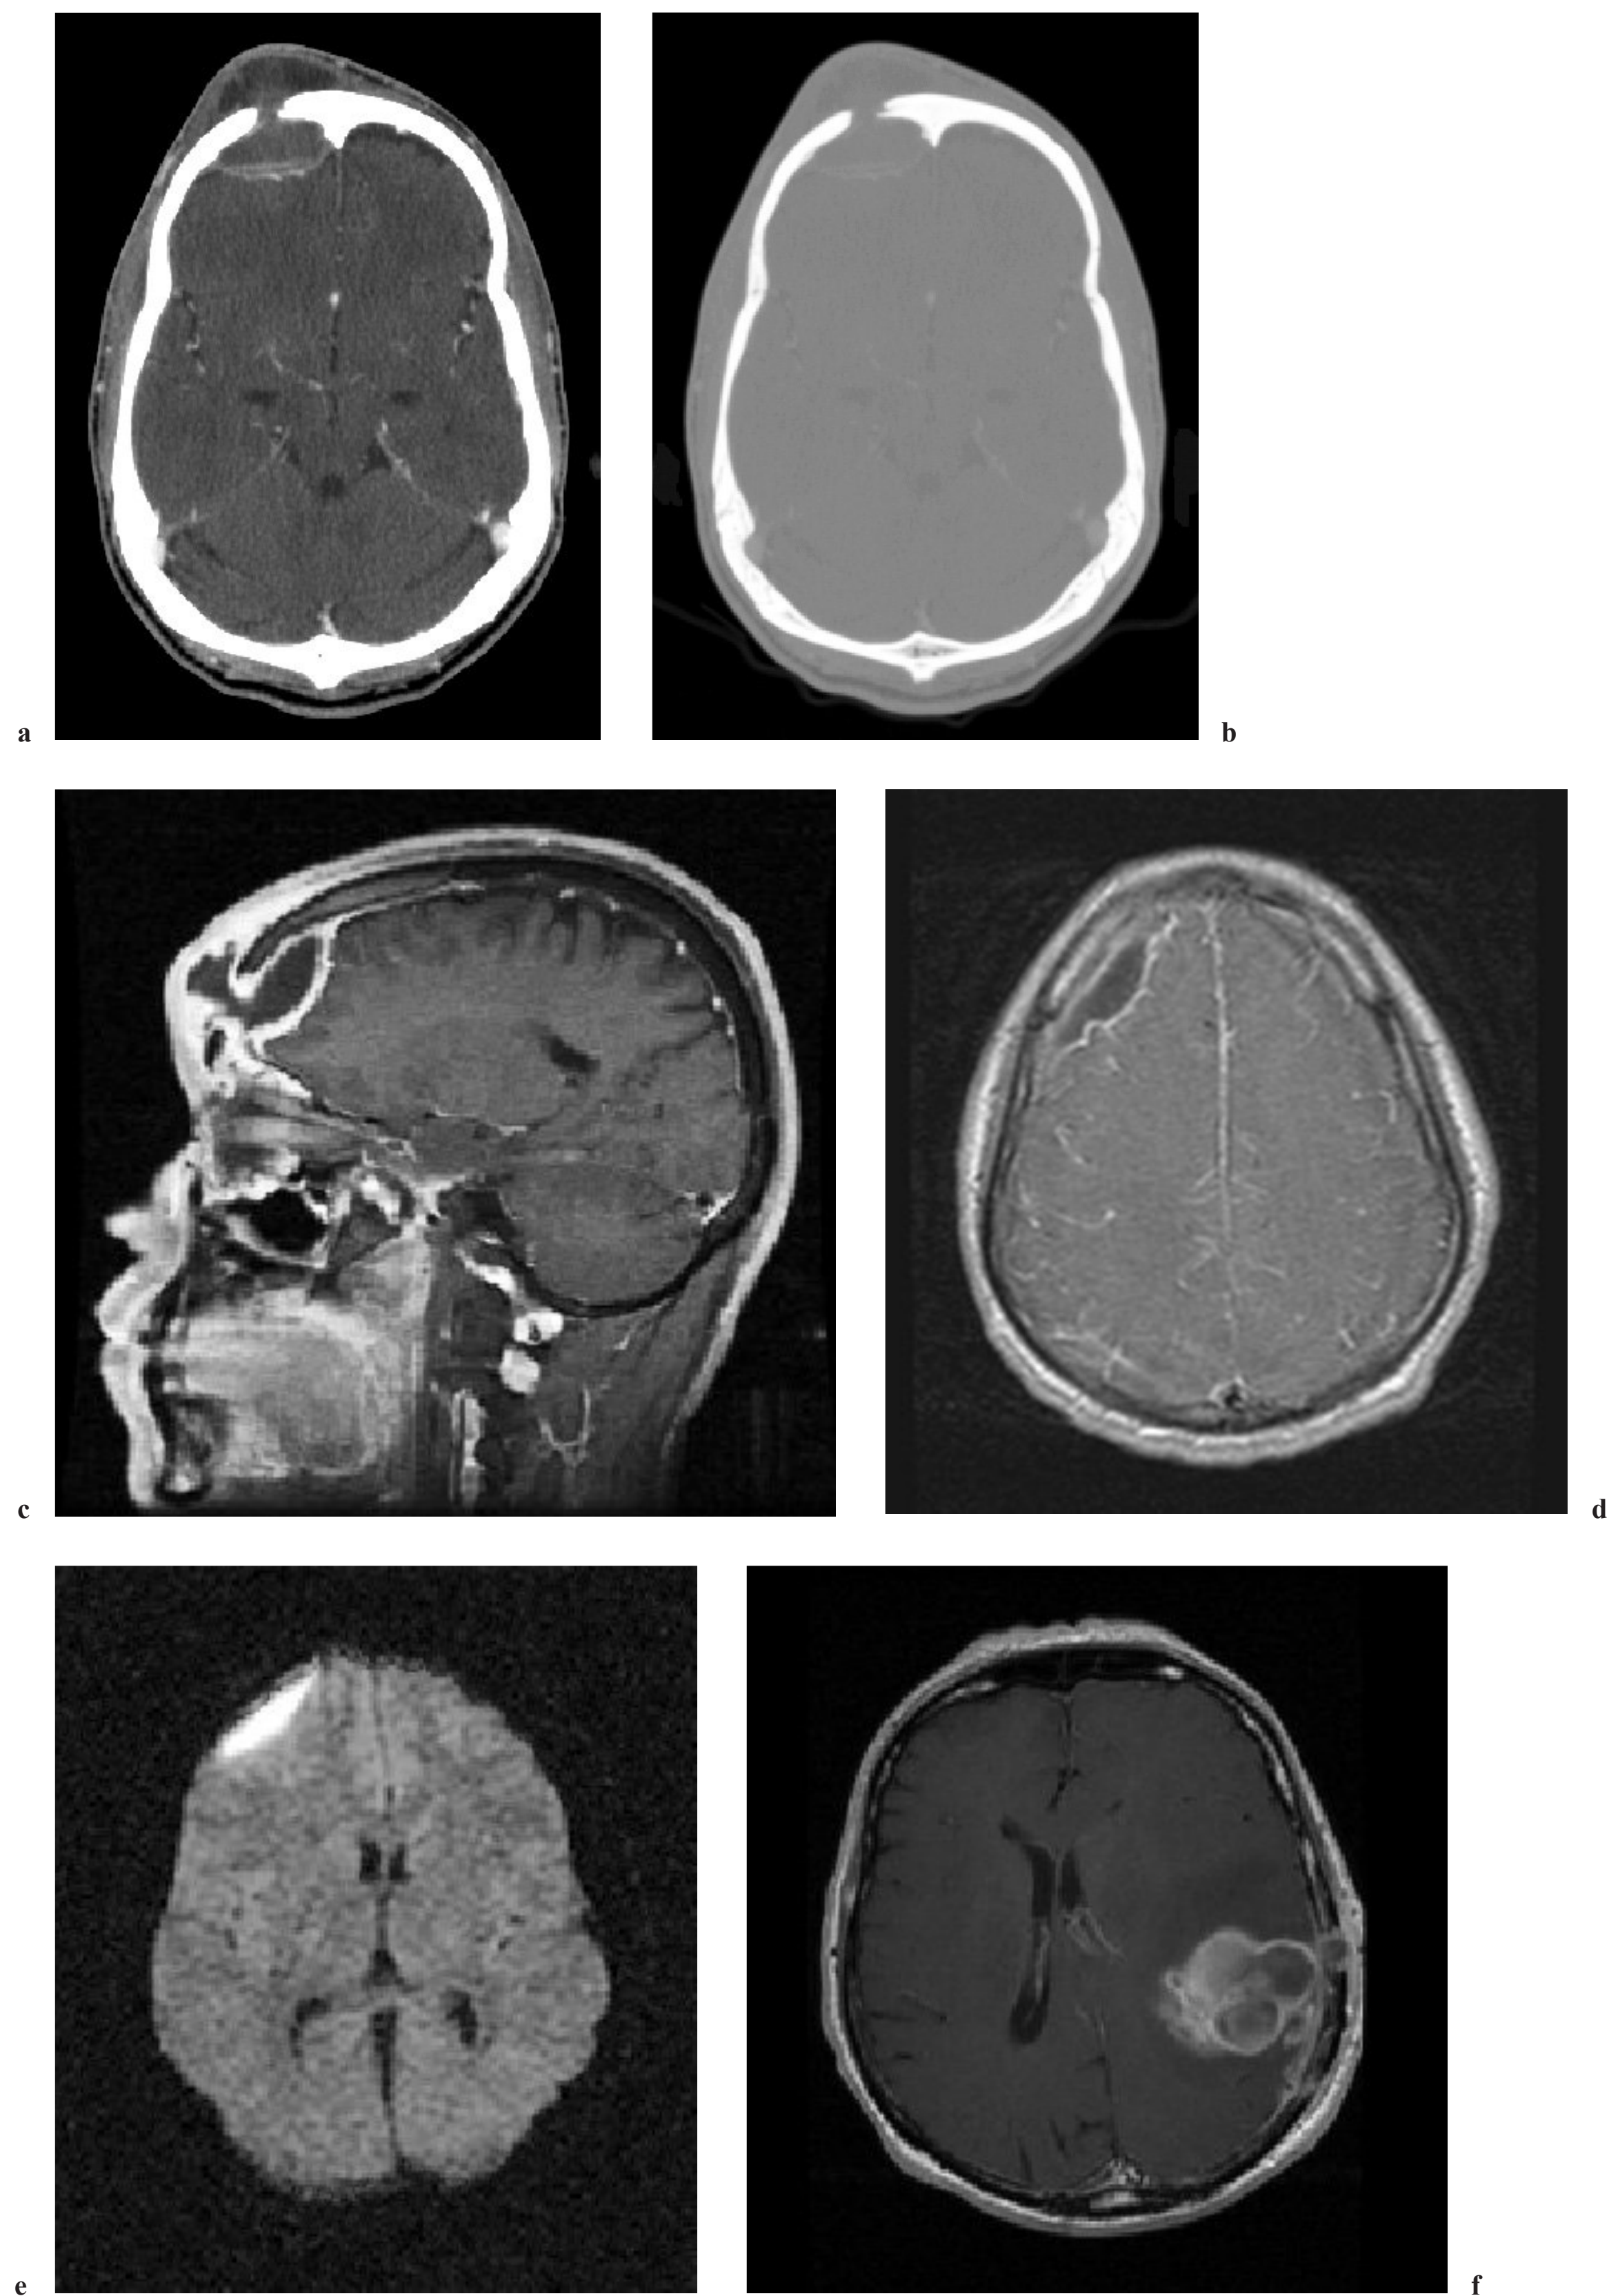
Axial CT (a) soft tissue and (b) bone windows, as well as (c) sagittal MRI post-gadolinium T1-weighted image demonstrating a Pott's puffy tumor. Note the extracranial soft tissue collection in communication with the epidural space, via the frontal air sinus. (d) Axial MRI post-gadolinium T1-weighted image demonstrating a right frontal subdural empyema. (e) The diffusion-weighted imaging sequence, in this setting, demonstrates hyperintense signal, indicating diffusion restriction. (f) Axial MRI post-gadolinium T1-weighted image demonstrating an intracerebral abscess with loculations and peripheral enhancement, extending to the local meninges.
